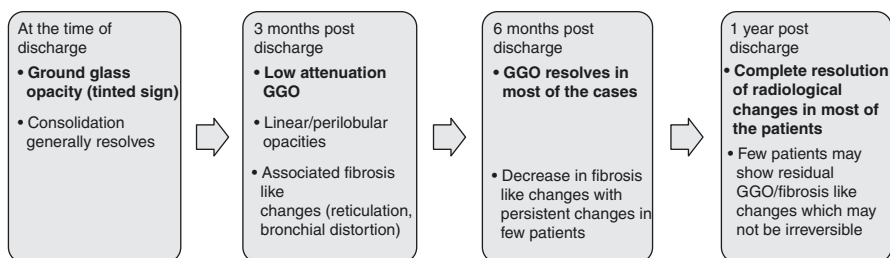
Evolution of imaging findings on CT over time in COVID-19 pneumonia
